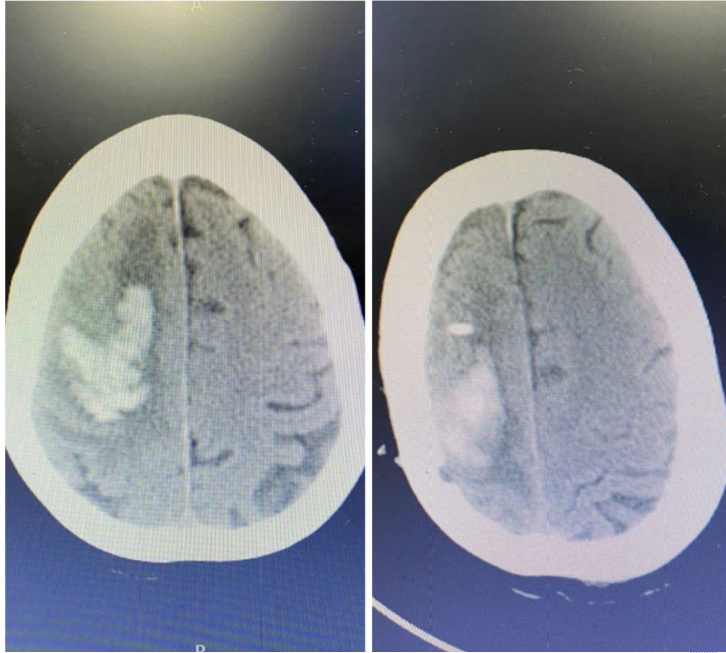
Intracerebral hemorrhage shown in Non contrast CT scan of brain (on right side) while Right parietal lobe intracerebral bleed with interventricular ipsilateral extension in CT scan of brain (on left side)
